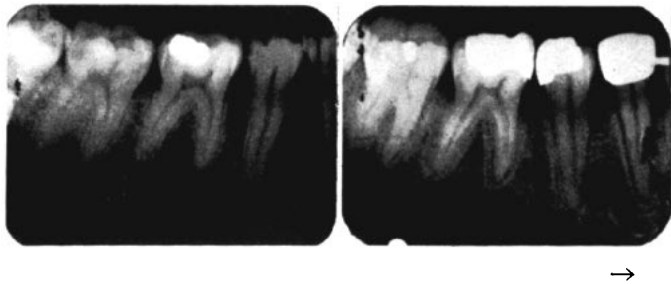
Intra-oral roentgenograms of the molar area (A) before and (B) after orthodontic treatment. The molars and bicuspids were so malposed as to be entirely out of function before orthodontic correction was accomplished. Note the prominent lamina dura as a result of the orthodontic tooth movement and the increased trabeculations of the supporting bone as a result of the normal function of the teeth. (Courtesy of Dr. A. Goldstein.)
